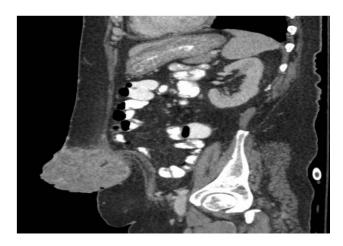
MRI with umbilical mass attached to peritoneum and mysentry.
